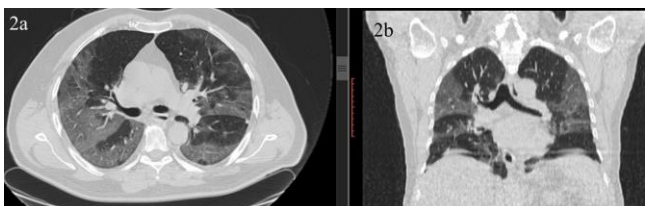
Axial and coronal plane images of Chest CT. In the form of bilateral peripheral consolidated areas, areas with the ground-glass density that affect the large part of both lungs are observed
